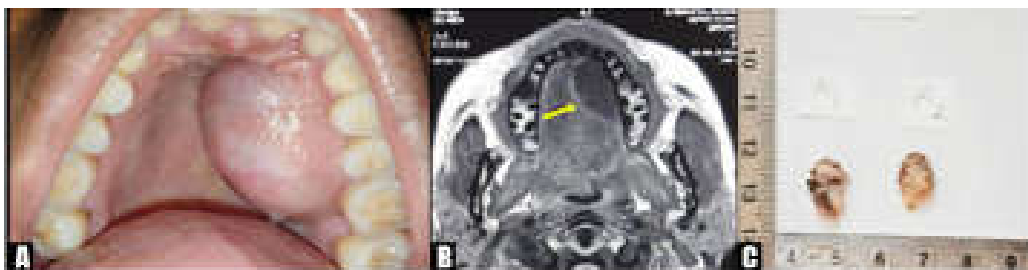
(a) Intraorally, a large, sessile, solitary mass with a smooth surface was seen on the hard palate extending from tooth 21 to 26 with normal overlying mucosa. (b) MRI scan exhibited a well-defined isointense mass with T1-weighted images in the hard palate extending from the 21 to 26 region. The mass obliterated the mid-palatine raphe (yellow arrow). (c) On gross examination, two tissues measuring 2x0.7cm in size, soft to firm in consistency, and reddish-pink to tan-grey in color were received.
